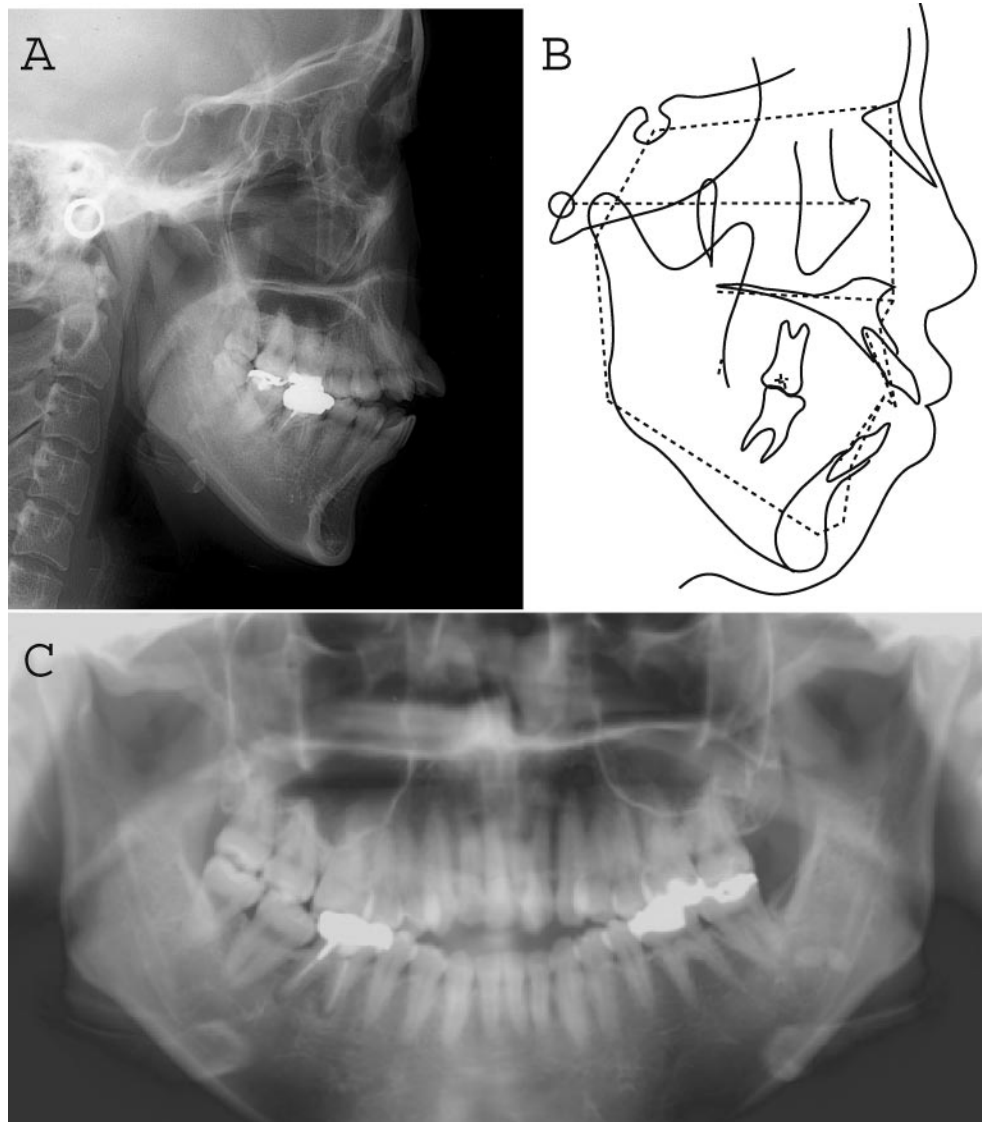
(A) Pretreatment cephalograph. (B) Tracing. (C) Panoramic radiograph. Tracing (solid lines) was superimposed with the mean profilogram (dotted line).
